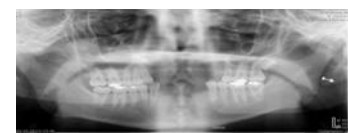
Pre-op panoramic X-ray view
